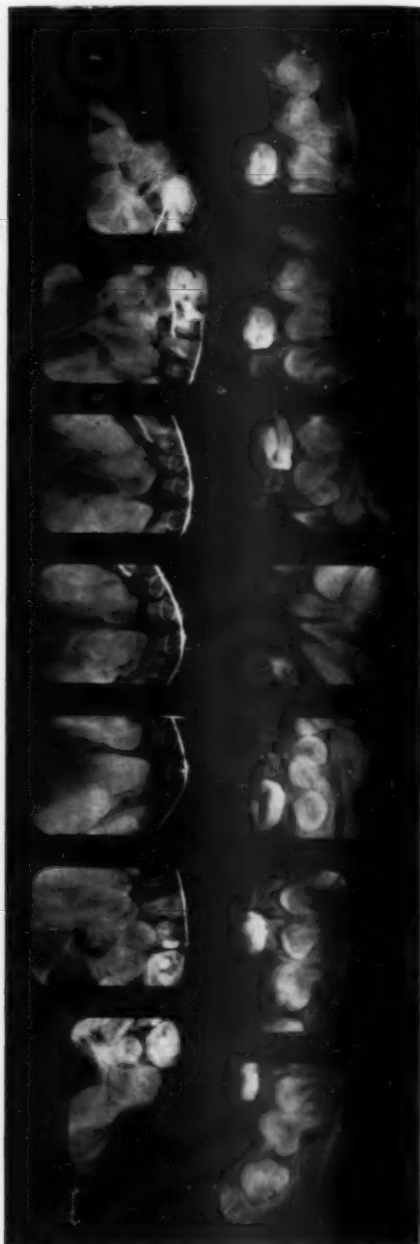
Roentgenograms made when the patient in Case 3 was 13 years of age. Resorption of deciduous upper and lower anterior teeth has progressed slowly. The unerupted permanent teeth have become more irregularly situated in the jaws.
